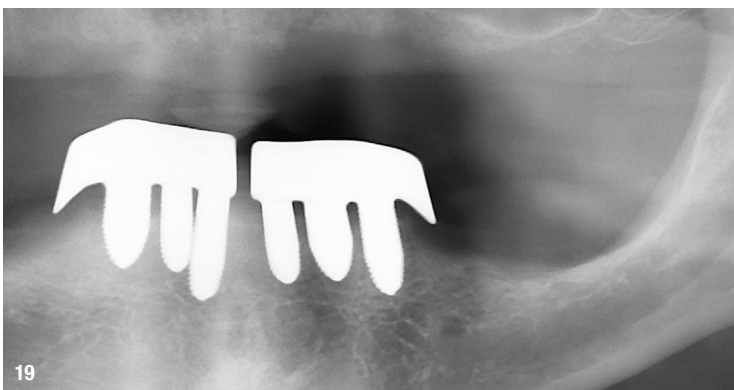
Confirmation radiograph after insertion of the complete denture in the lower jaw.
